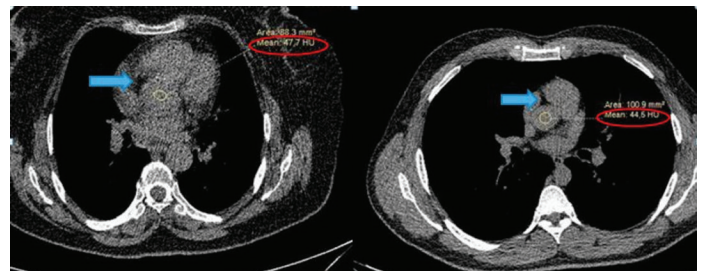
Evaluation of CT image quality of two different patients.
